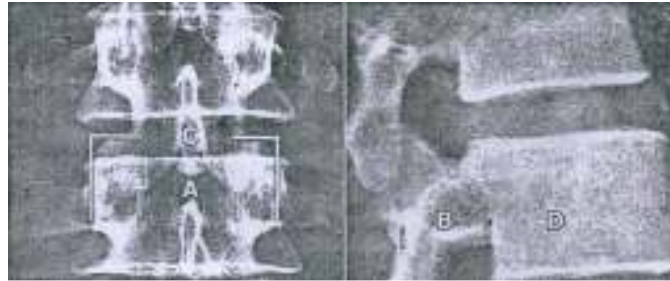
Showing anteroposterior and lateral radiographs of the lumbar spine
